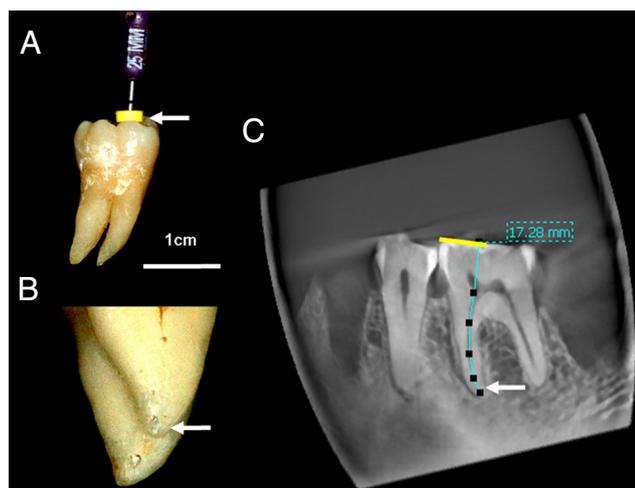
(A and B) Gold standard measurements of a mandibular molar between (A) the coronal reference point (arrow) and (B) the AF (arrow). (C) The CBCT length was defined as the distance between the cuspal edge (yellow line) in the projected extension line of the cervical one-third canal (blue line) and the major foramen (arrow).
